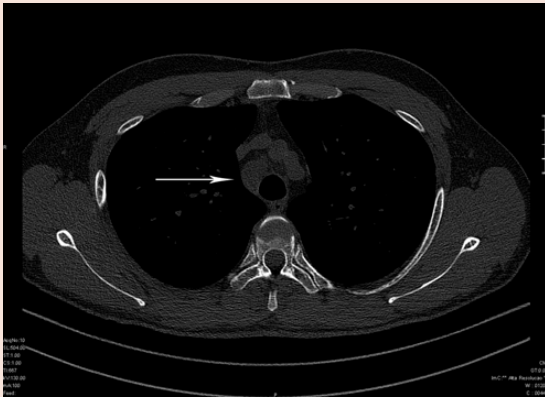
High-resolution CT showing enlarged paratracheal lymph nodes (arrow).
